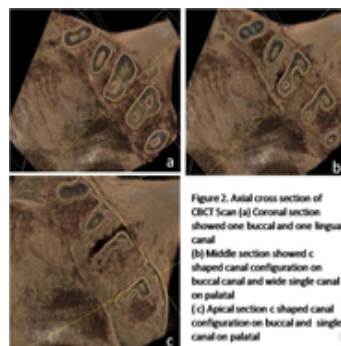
Axial cross section of CBCT Scan (a) General section showed one buccal and one lingual canal (b) Middle section showed C shaped canal configuration on buccal canal and wide single canal on palatal (c) Apical section C shaped canal configuration on buccal and single canal on palatal
